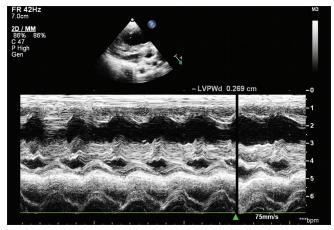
Parasternal long-axis view showing posterior wall thickness in M-mode
